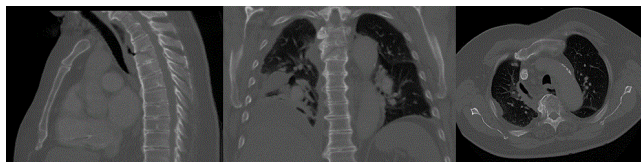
Sagittal, Coronal and Axial CT scans - Oblique fracture T4 vertebral body, free mediastinal gas. Posterior to esophagus at T4 level.
